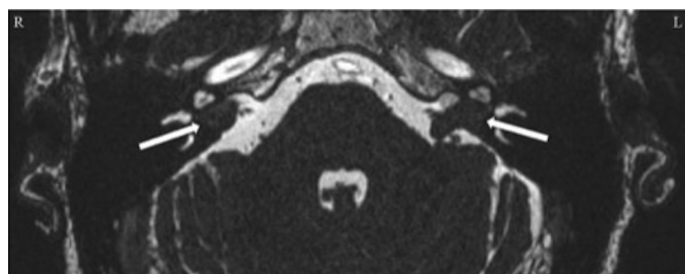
Posterior fossa magnetic resonance imaging demonstrating bilateral vestibular schwannomas (arrows) in a 54-year-old male with NF2. The patient underwent radiotherapy on the right side to stabilize the tumor and received subsequent ipsilateral cochlear implantation due to profound bilateral hearing loss. NF2, neurofibromatosis type 2; L, left; R, right.
